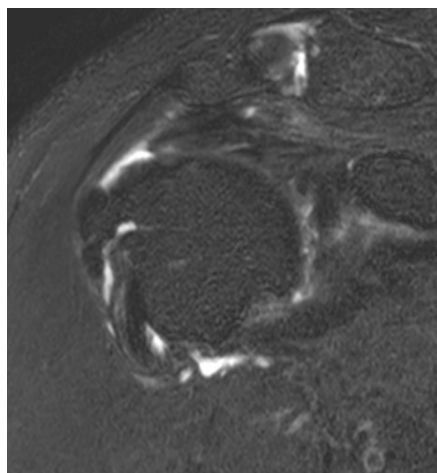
Oblique coronal fat-suppressed T2-weighted MRI scan. Fluid signal intensity.
